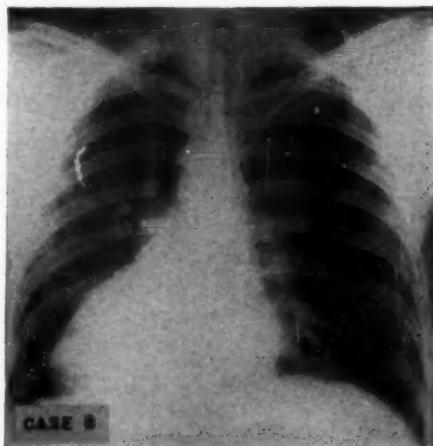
Chest x-ray in case of aortic-pulmonary artery communication with pulmonic stenosis and situs inversus.
